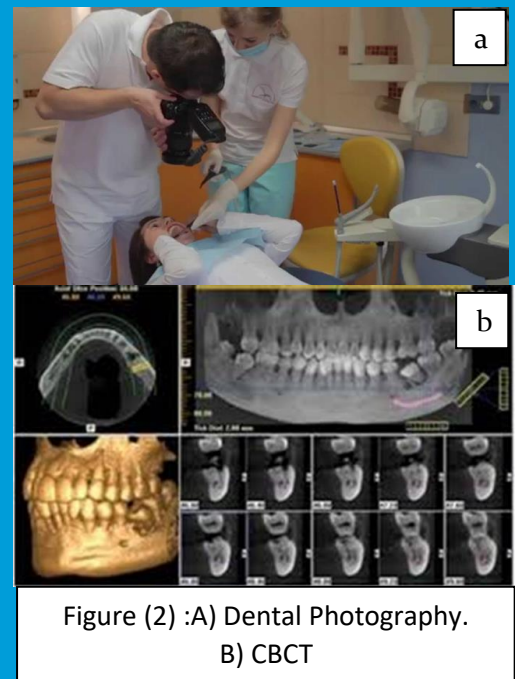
A) Dental Photography. B) CBCT
